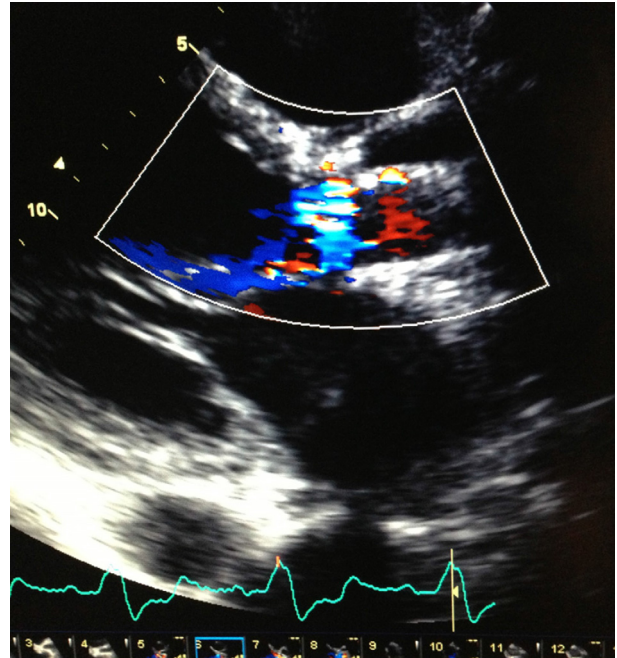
Transthoracic echocardiogram demonstrating mild-moderate perivalvular leak s/p valve-in-valve deployment.
